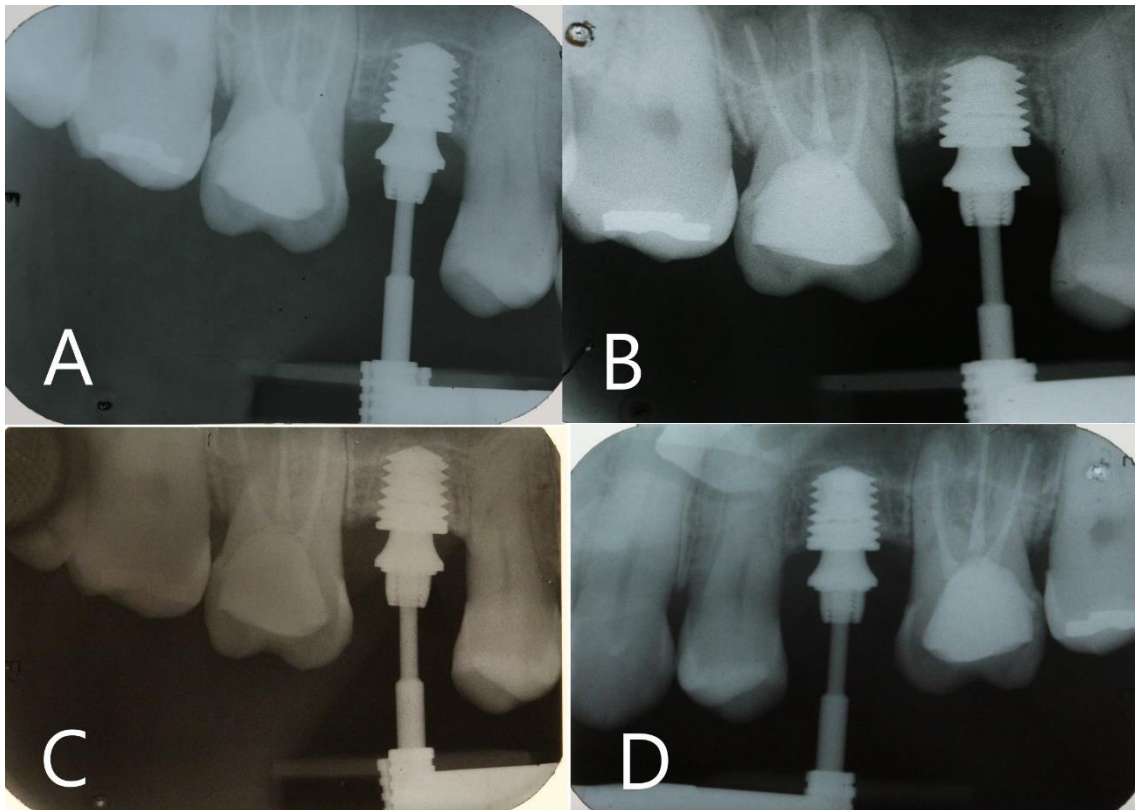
Radiographic Image. A. T1 Immediate post-operative follow-up. Figure 6. Radiographic Image. B. T2 1 year follow-up. Figure 6. Radiographic Image. C. T3 3 year follow-up. Figure 6. Radiographic Image. D. T4 5 year follow-up.
